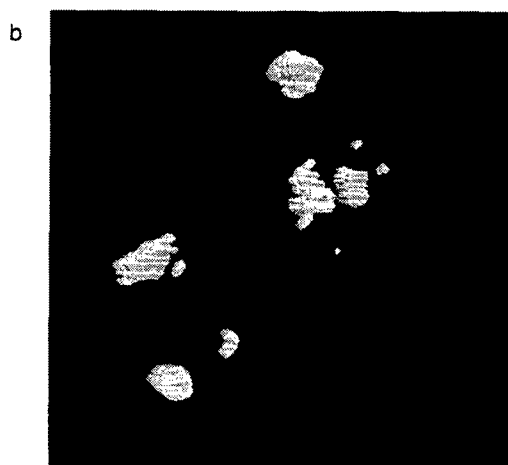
A radiograph of a benign cluster of calcifications (a). Also shown are 2 reconstructions of the cluster (b,c). The reconstructions show plate-like calcifications arranged in a spherical manner about a lucent center. This is typical of a fibroadenoma.
